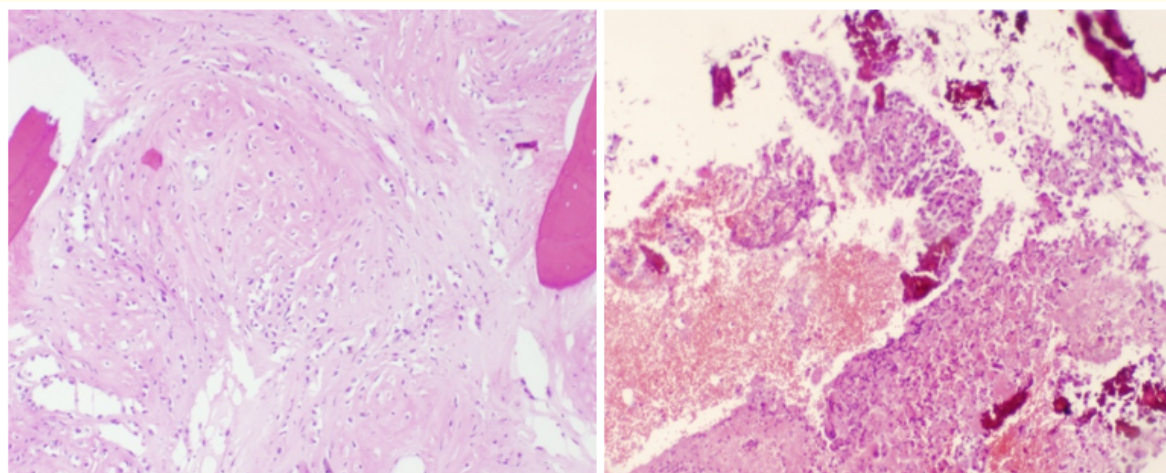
Osteoblastic OS-permeating bony spicules pre CT biopsy of OS-necrosis.
